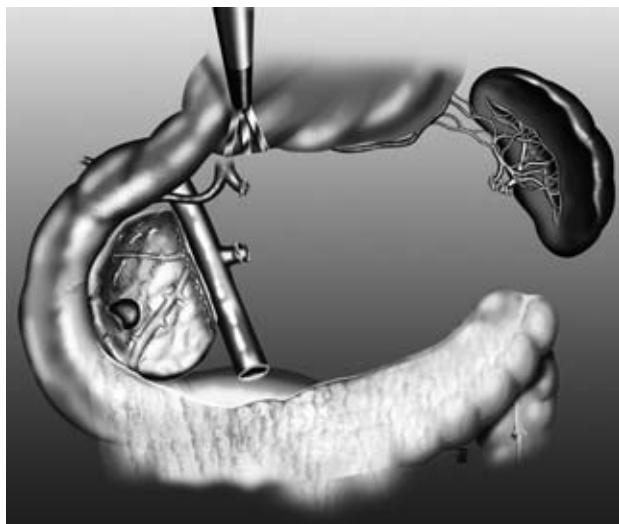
Spleen-preserving 70–80% distal pancreatectomy without splenic vessels preservation. It is mandatory to preserve the short gastric vessels and if possible the left gastroepiploic vessels. Laparoscopic ultrasonography is also mandatory to rule out a macroscopic tumor in the head of the pancreas. In case of localized tumor in the pancreatic head, tumor enucleation should be attempted.
